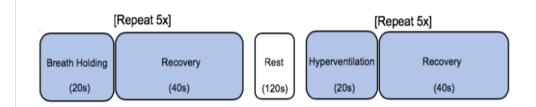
Functional transcranial Doppler protocol for cerebrovascular reactivity (CVR). Each participant completed five trials of CVR testing protocol.
